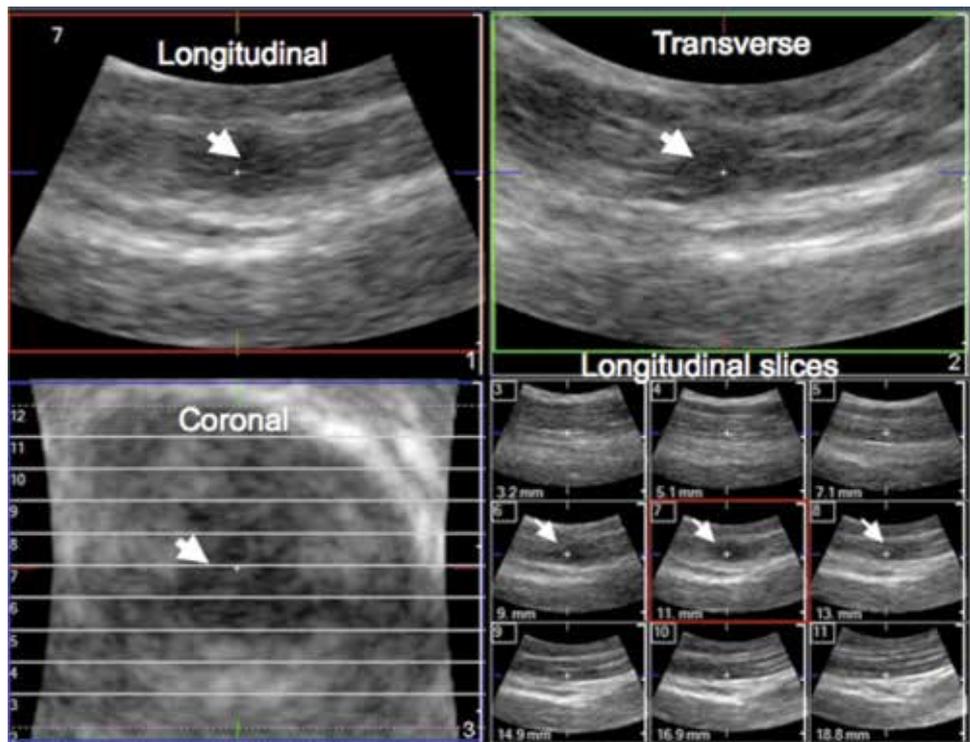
Sonography of muscle trigger points (reproduced from Sikdar et al. [59], with permission from Elsevier).
